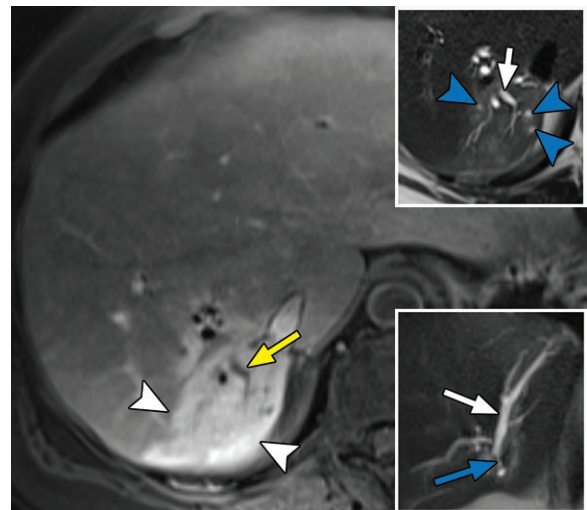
THID from biliary abscesses and obstruction in a 57-year-old woman after Roux-en-Y hepaticojejunostomy after bile duct injury. Axial T1-weighted arterial phase MR image shows THID in hepatic segment VII (white arrowheads) with dilated peripheral bile ducts (yellow arrow). Axial (top inset) and coronal (bottom inset) T2-weighted MR images show biliary ductal dilatation (white arrows) owing to a hepaticojunal anastomotic stricture (blue arrow) causing biliary microabscesses (blue arrowheads) as the source of THID.
